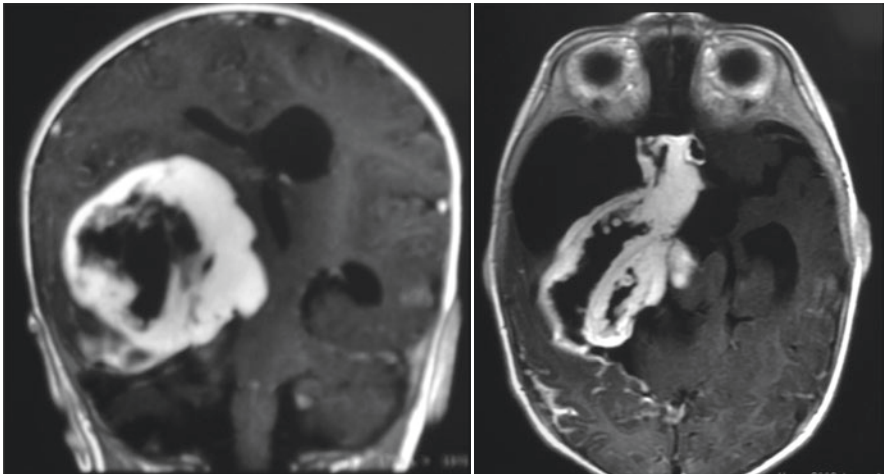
MRI: Optic pathway tumor extending toward the optic radiations on the right. No surgical intervention was contemplated
